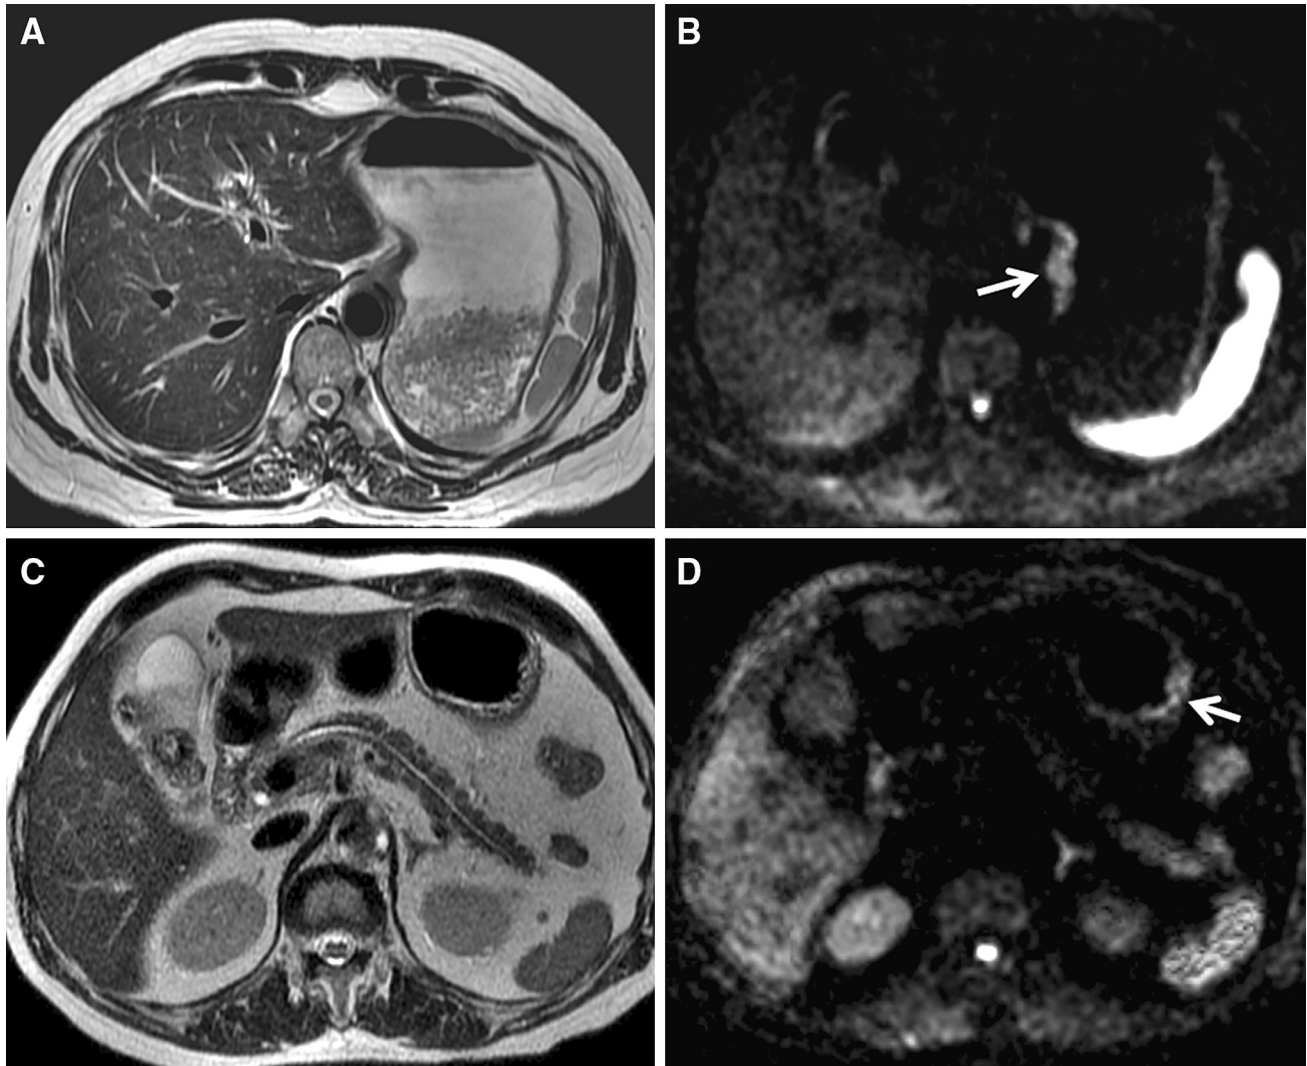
Cancer detection of non-enhanced MRI combined with DW-MRI (a) FRFSE T2WI, the cardiac wall displayed a thickness of the gastric wall < 8 mm and no detectable thickness difference compared to nearby normal gastric wall and without a signal difference. b FRFSE T2WI, the cancer appeared as a high signal on DW-MRI (*white arrow*). c SSFSE
